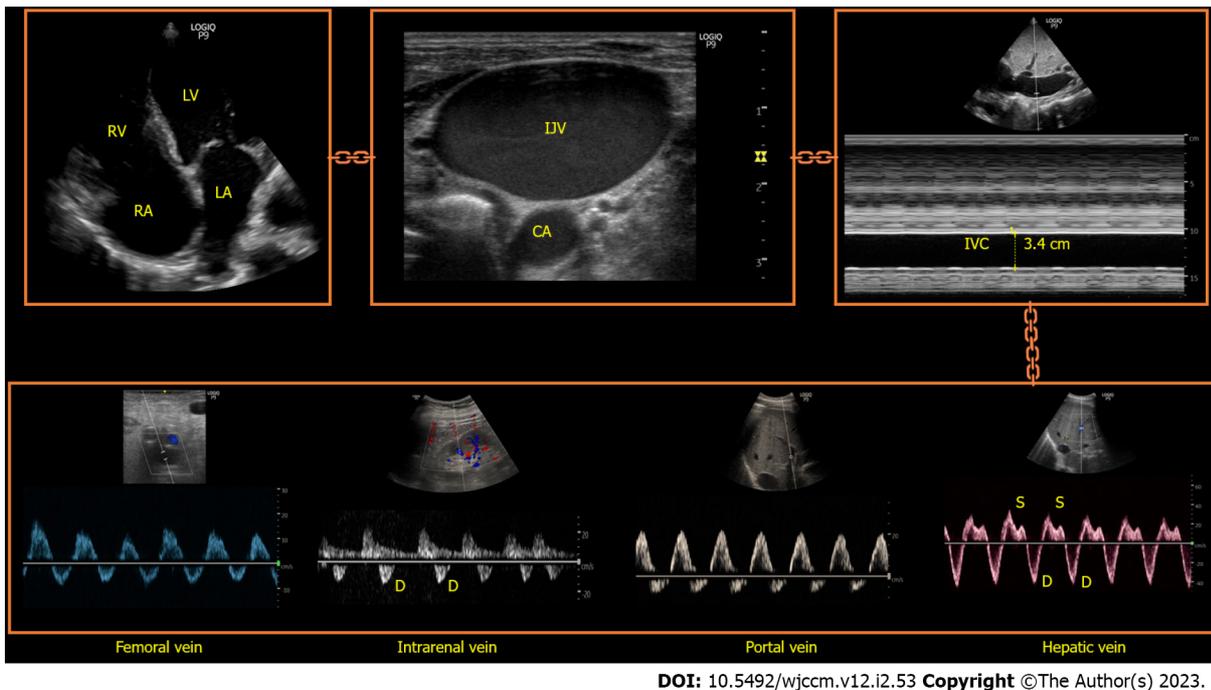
The chain of venous congestion: Apical view of the heart is shown in the upper left corner where bulging of the interatrial septum into the left atrium can be noted suggestive of high right atrial pressure. Next image shows significantly dilated internal jugular vein followed by a plethoric inferior vena cava. Lower panel represents the commonly assessed Doppler parameters to assess systemic venous congestion, all of which are severely abnormal. Please see Figure 3 for the normal appearance of these waveforms and Figure 2 for venous excess ultrasound score grading. RA: Right atrium; RV: Right ventricle; LA: Left atrium; LV: Left ventricle; CA: Carotid artery; S: Systolic wave; D: Diastolic wave.
